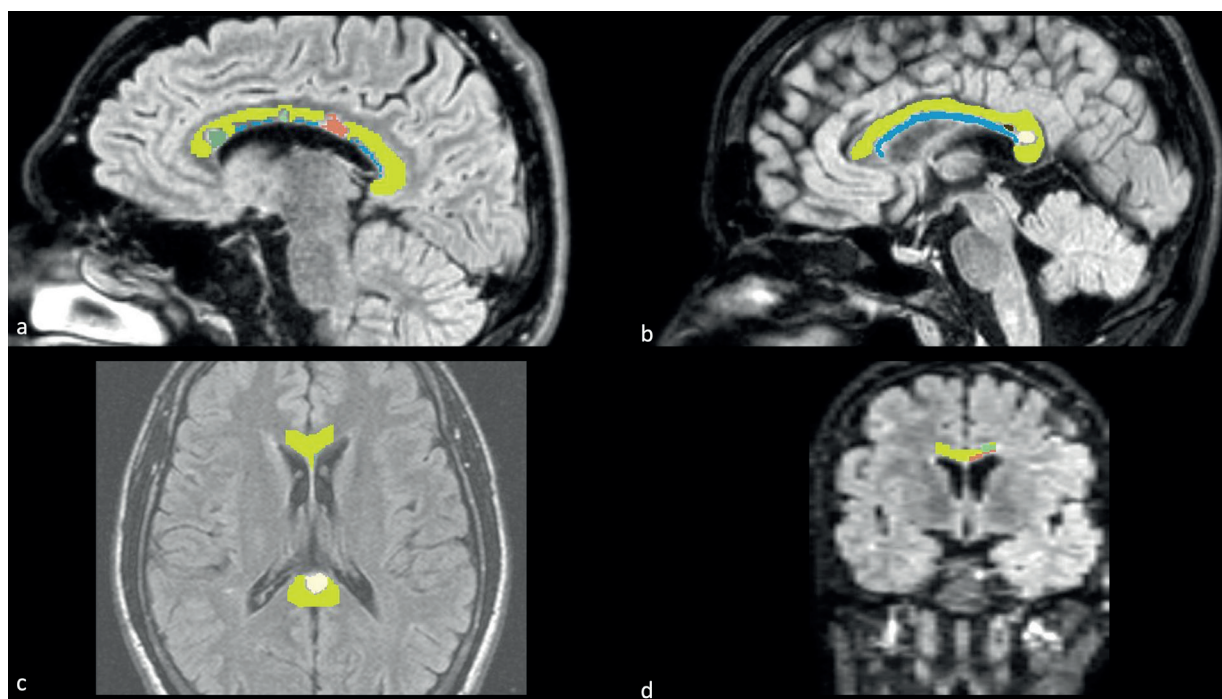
Representative CC contouring and segmentation on four different MS subjects. A 30 y/o male subject (panel a) FLAIR-sequence, sagittal view; corpus callosum contoured with different color: dark green (*lesion localized anteriorly, at genu level*), light green (*lesion localized in the middle of the body*), light brown (*lesion located more posteriorly in the body*) and light blue (*confluent lesion*); yellow represents the *corpus callosum residual*. For each slice the lesions were outlined first, and then, the corpus callosum residual. A 21 y/o female subject (panel b) FLAIR-sequence, sagittal view: in light blue extended *confluent lesion*³⁰; in the splenium, *two further lesions* are detectable (dark brown and white), in yellow the *corpus callosum residual*. A 36 y/o male subject, same of panel (panel c). FLAIR-sequence, axial view: a *demyelinating lesion at the level of splenium is clearly visible* in white. In yellow the *corpus callosum residual*. Axial images, as well as the coronal ones, were used to check the contour performed in sagittal. A 19 y/o female subject same of panel b (panel d). FLAIR-sequence, coronal view: *two distinct lesions* are visible, *one more caudal and medial* in light brown and *one more cranial, at the left lateral limit of the corpus callosum*, in light green; in yellow the *corpus callosum residual*
